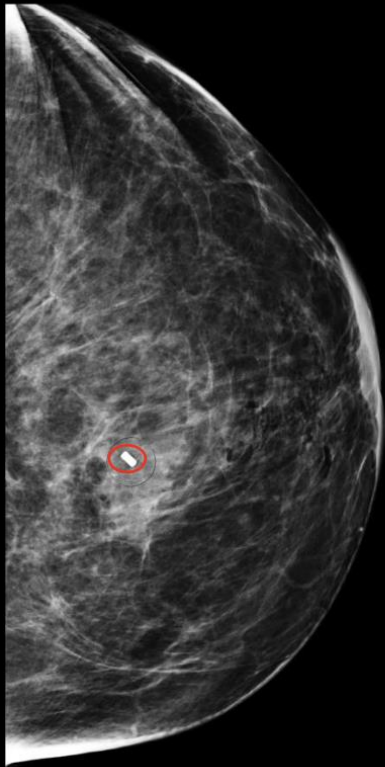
MRI Post Biopsy
